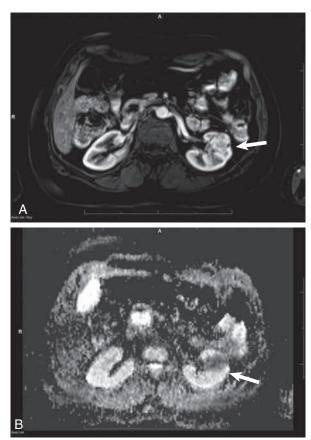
MRI of renal tumor. T1-weighted contrast enhanced image showing enhancing left renal tumor.
